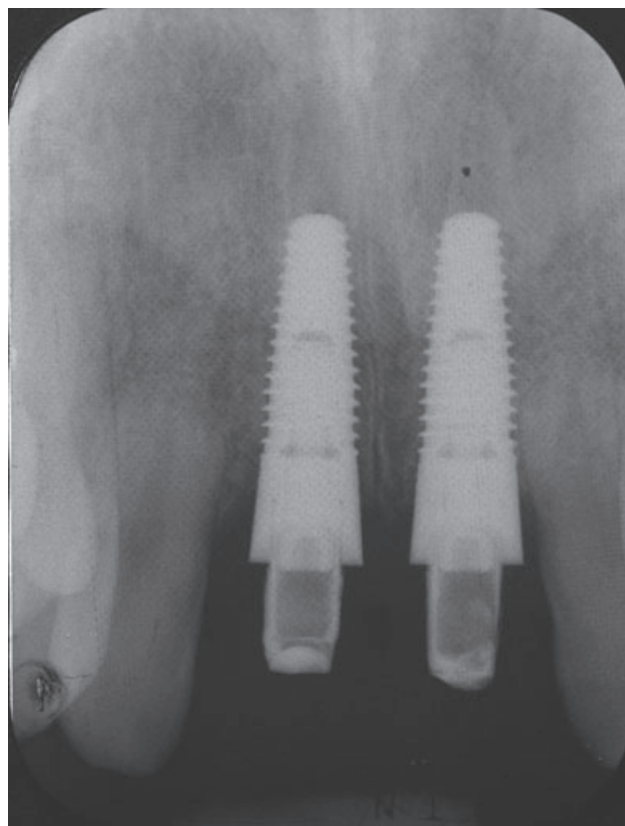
Radiographic view at 2 months postsurgery.
